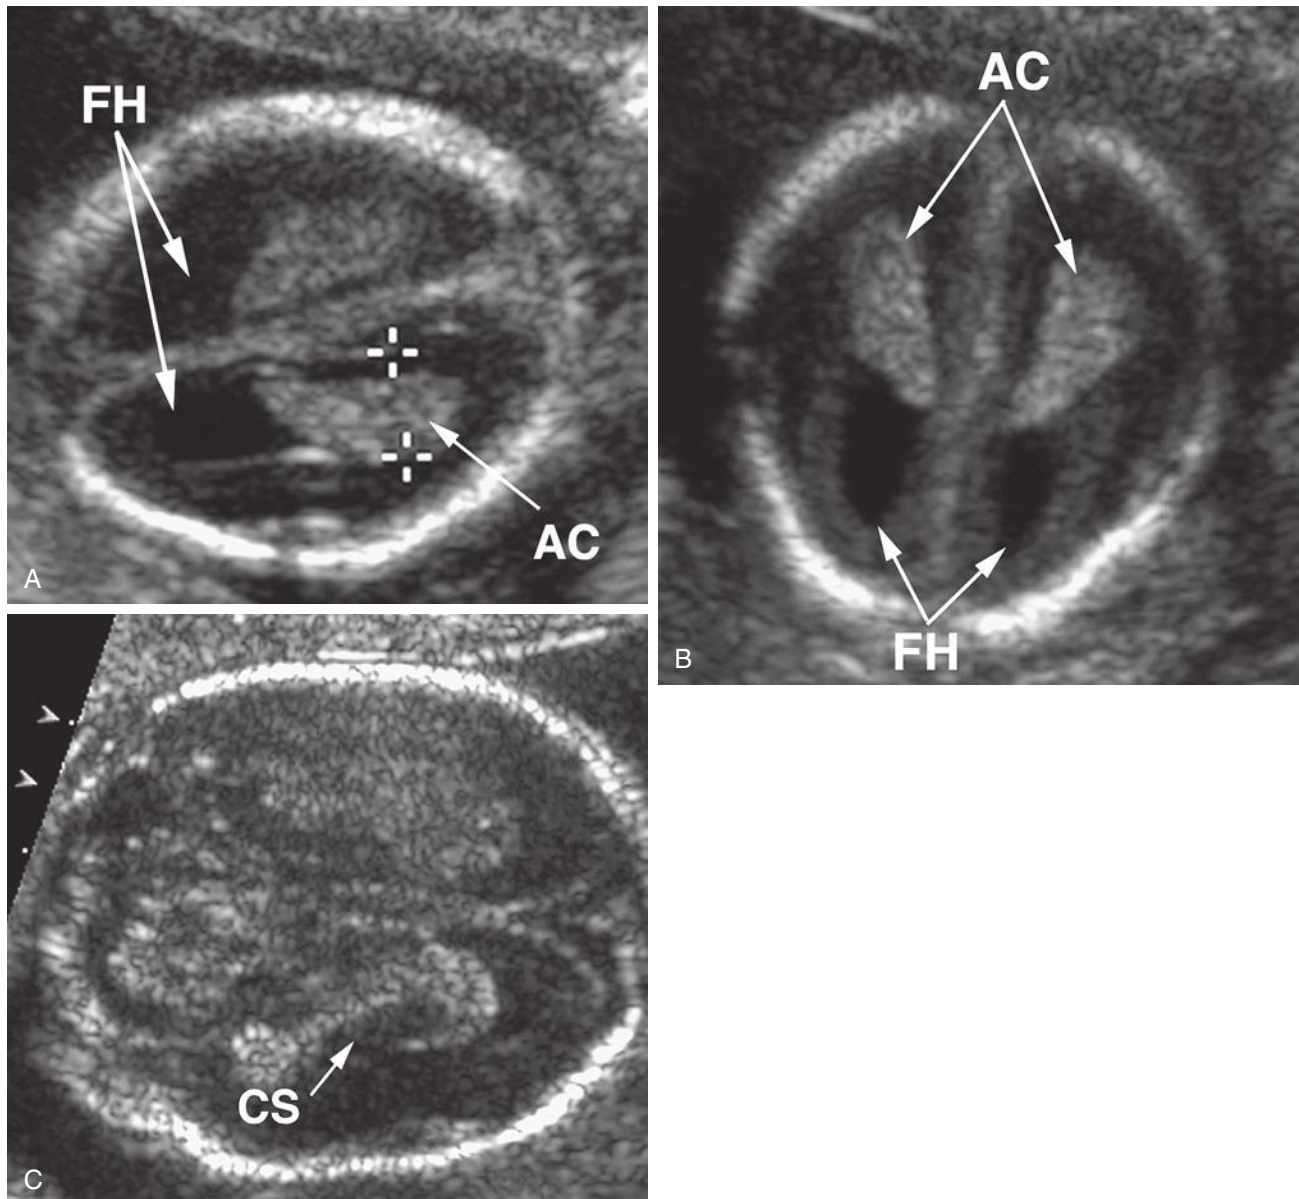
Three axial sonograms through the lateral ventricles of early second trimester fetuses. A, Axial sonogram demonstrates degradation of visualization of the near ventricle due to calvarial reverberation artifact. Note the difference in clarity of the frontal horns (FH). AC, atrial choroid. B, By imaging through the posterior fontanelle, calvarial reverberation is nearly eliminated, and the frontal horns are now seen with equal clarity. C, At this early stage of development the corpus striatum (CS) is prominent and indents the ventricular choroid. This should not be mistaken for an abnormality (sometimes, when more lucent, it masquerades as a choroid plexus cyst).
